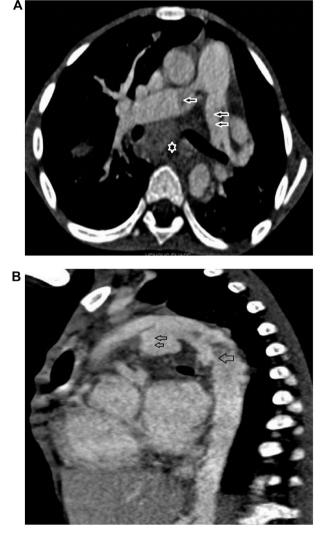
(A) Computed tomography image showing massive vegetation (filling defects) at mid LPA (double arrow) and RPA (single arrow) with distal LPA aneurysm. There is presence of mediastinal inflammatory tissues (star). (B) Computed tomography image showing massive vegetation (filling defects) at upper and mid descending aorta with aneurysmal dilatation (single arrow). Patent ductus arteriosus is aneurysmal and loaded with thrombus (double arrow).
